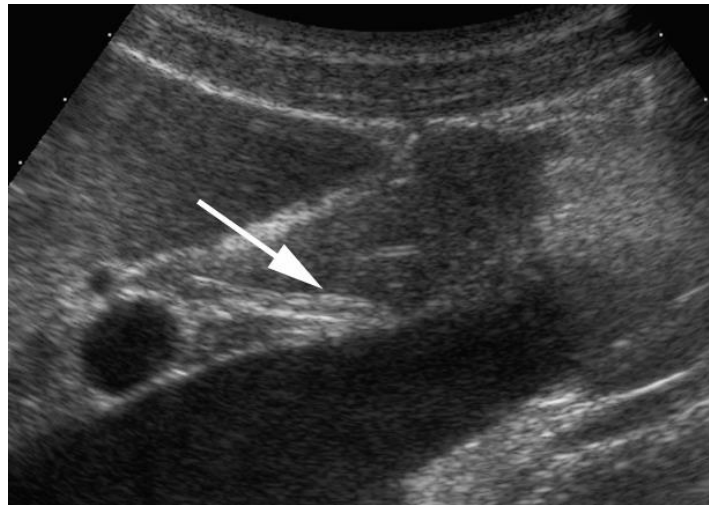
Pancreatic duct. Ultrasound oblique scan of the pancreatic body with visualisation of the main pancreatic duct (arrow).
